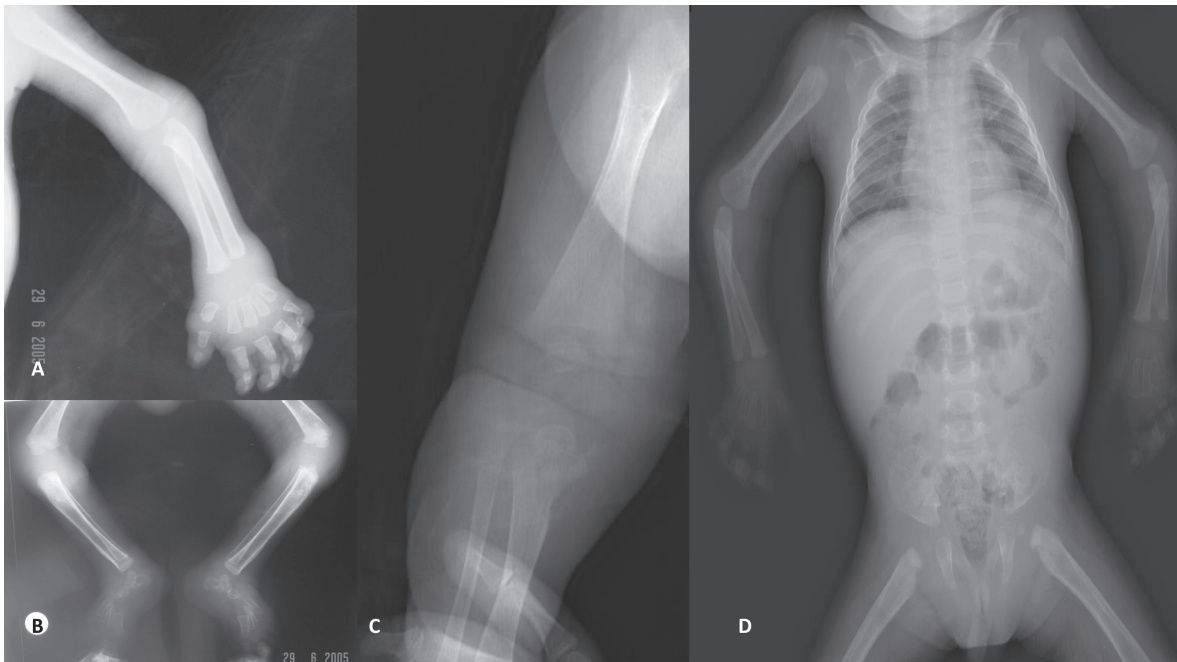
X-ray images reveal osteopenia, camptodactyly, and periosteal reactions. (A, B: patient 1, C: patient 6, D: patient 7).
